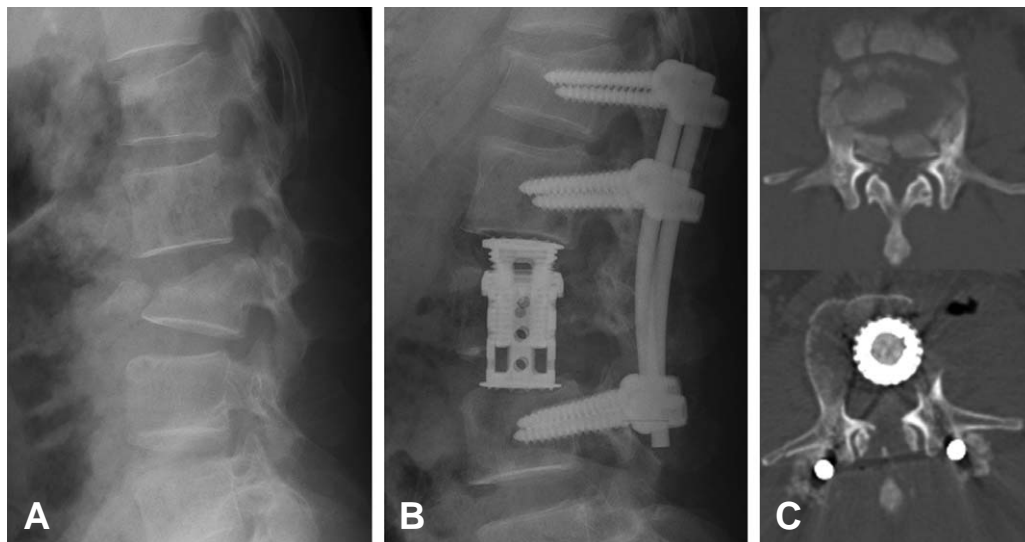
A 43-year-old man with AO type B and incomplete neurologic deficit. (A) Lateral radiograph with anterior translation and segmental kyphosis. (B) Postoperative radiograph after anterior and posterior surgery. (C) Pre- and postoperative CT axial images shows complete decompression of bony fragment in the spinal canal.
